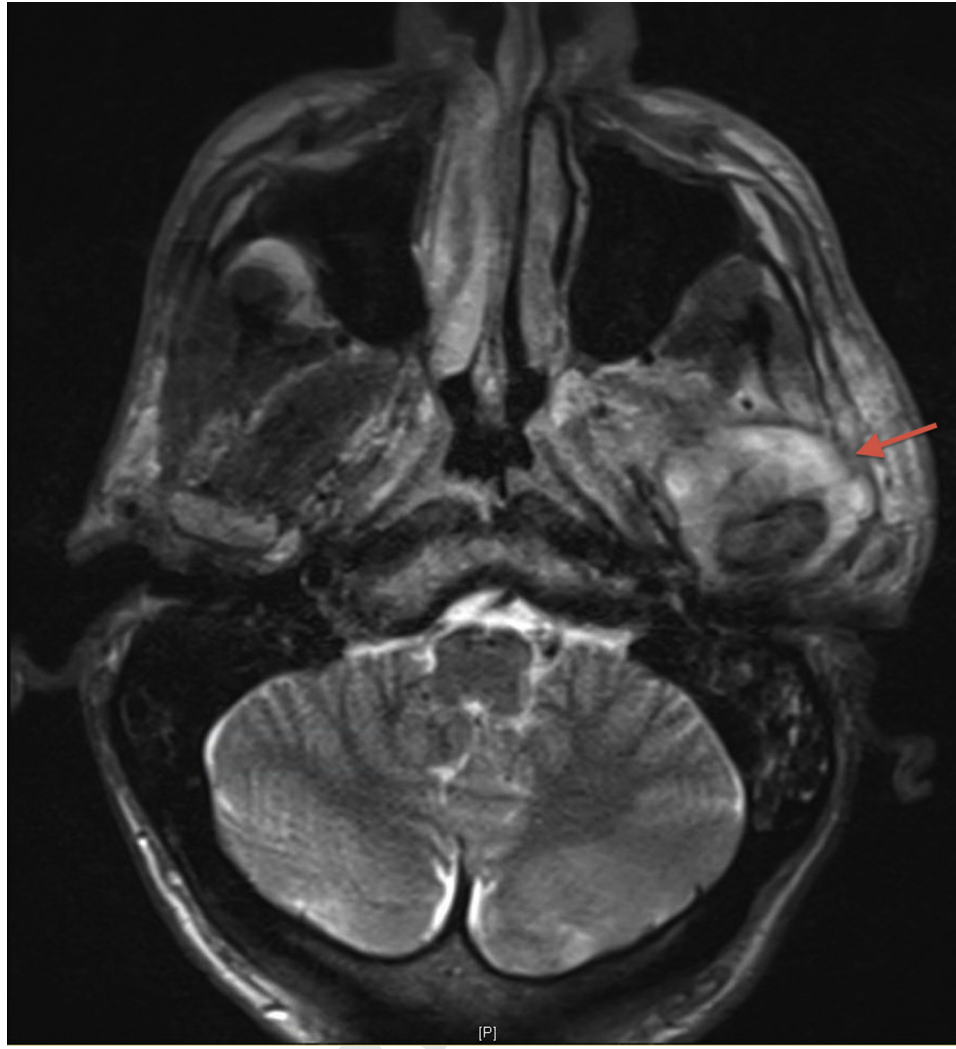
Case 1. Preoperative maxillofacial contrast T2-weighted magnetic resonance image on day 30 shows fluid collection (arrow) adjacent to the left temporomandibular joint with marked enhancement in the periphery of the collection, adjacent soft tissues, and muscles of the masticator space suggestive of infectious etiology.
